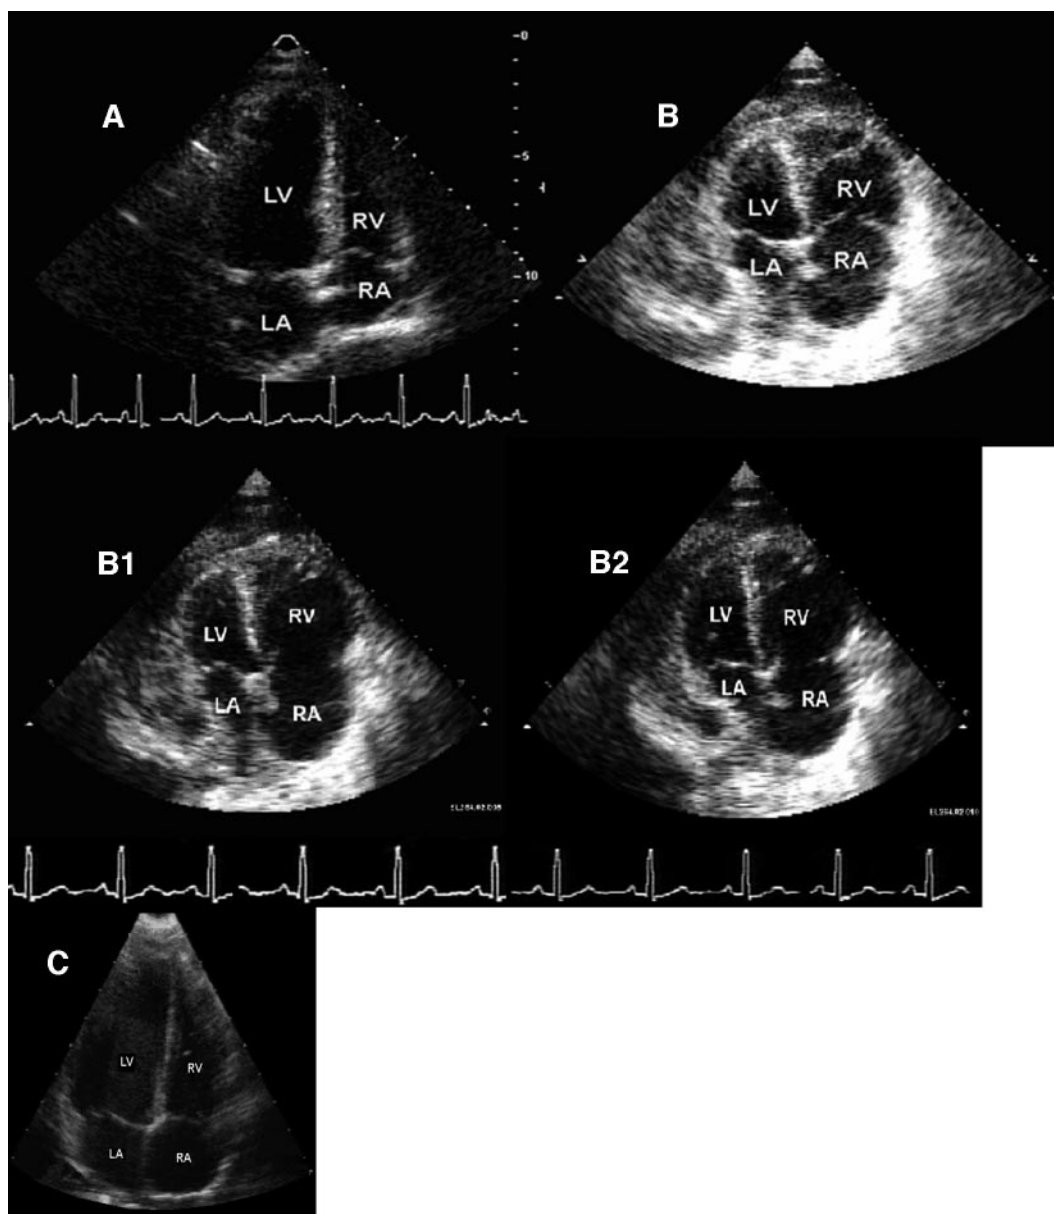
Four-chamber view from a two-dimensional transthoracic echocardiogram. A: Normal right-heart chamber dimensions (prior to surgery). B: Marked enlargement of the right atrium and ventricle, with alteration of the right-ventricle shape, which is also hypokinetic. B1: End-systole image. B2: End-diastole image. C: Echocardiogram after discharge. RA = right atrium. LA = left atrium. RV = right ventricle. LV = left ventricle.
